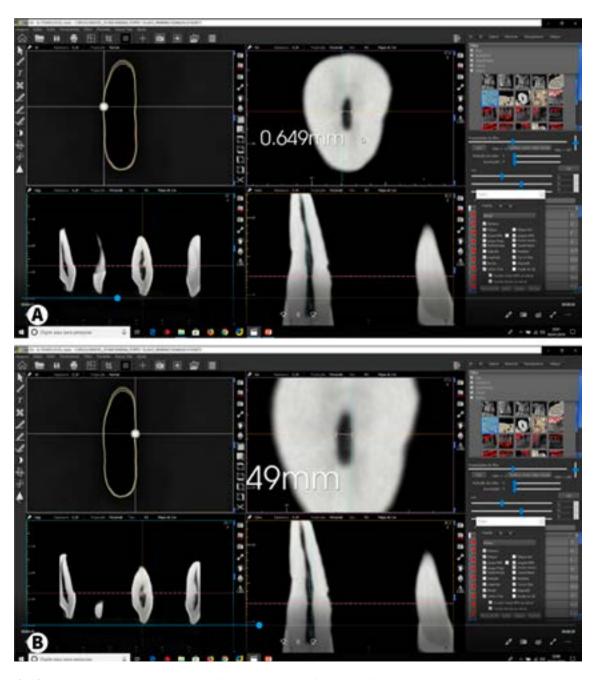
(A-B) CBCT report show the determination of the actual position of the edges of the root canal to be dimensioned with the visualization measured in micrometers. The measurements are checked on both sides of the root canal surfaces.
